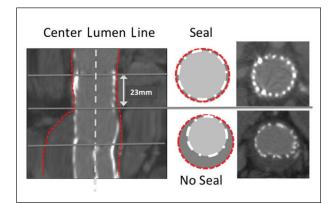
Method for measuring seal length on a CTA using center lumen line reconstruction.
